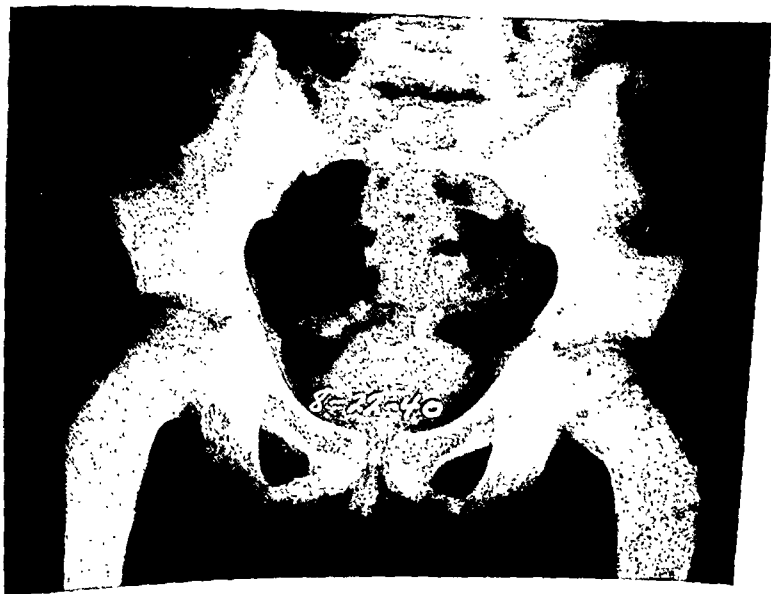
X-ray of head and neck of femur taken Aug. 22, 1940, of a boy 8 years of age. Became ill July 9, 1940. *Staphylococcus aureus* recovered from the blood stream. Treated with sulfapyridine. Became afebrile Nov. 1, 1940.
